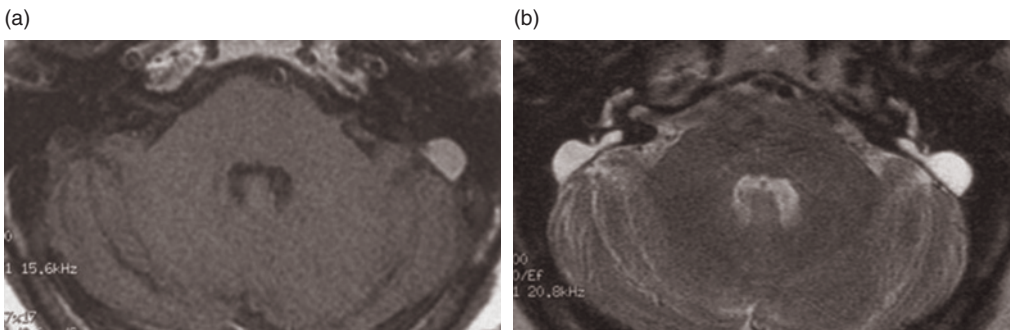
T1-weighted (a) and T2-weighted (b) axial MR images. Bilateral dilation of the endolymphatic duct and sac. The high hyperintensity of the left sac on both T1 and T2-weighted images could be due to protein-rich and hyperosmolar endolymph.
